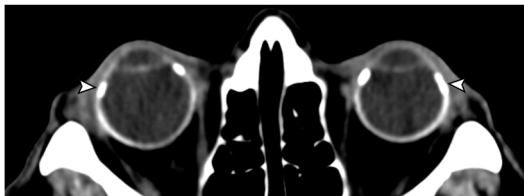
Axial CT orbits demonstrating bilateral senile calcific scleral plaques with characteristic calcifications at the insertions of the medial and lateral recti muscles (arrowheads).
